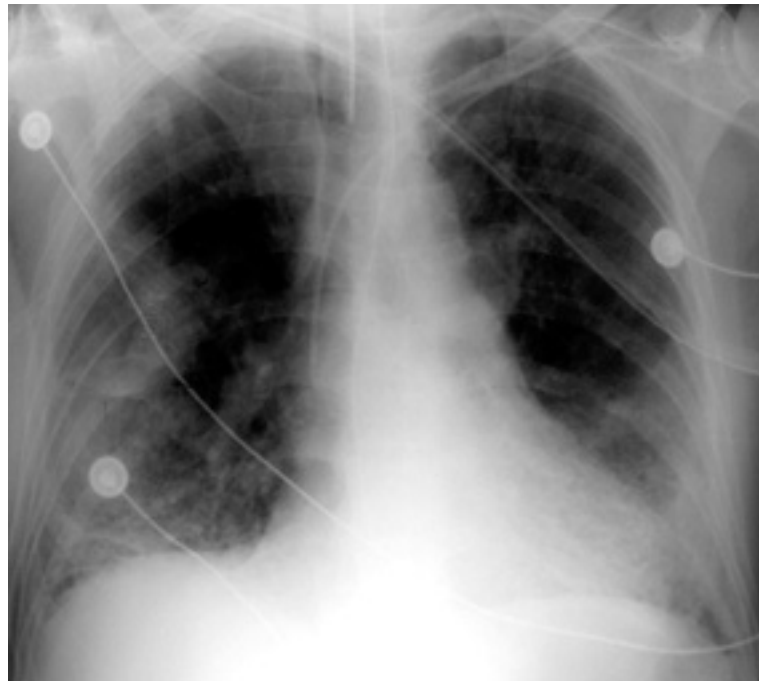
Plain radiograph of acute lung injury (ALI). Reproduced from Medicine Net (<http://www.medicinenet.com>).*
